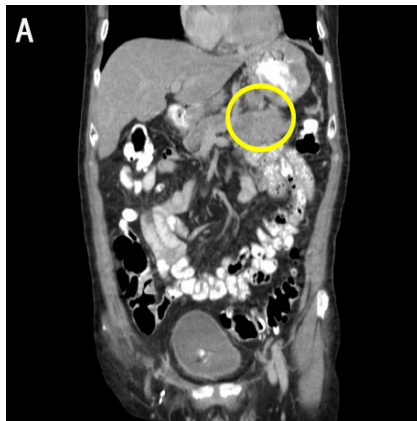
Coronal and transverse computed tomography of the abdomen and pelvis showing a large exophytic mass posterior to the stomach.
